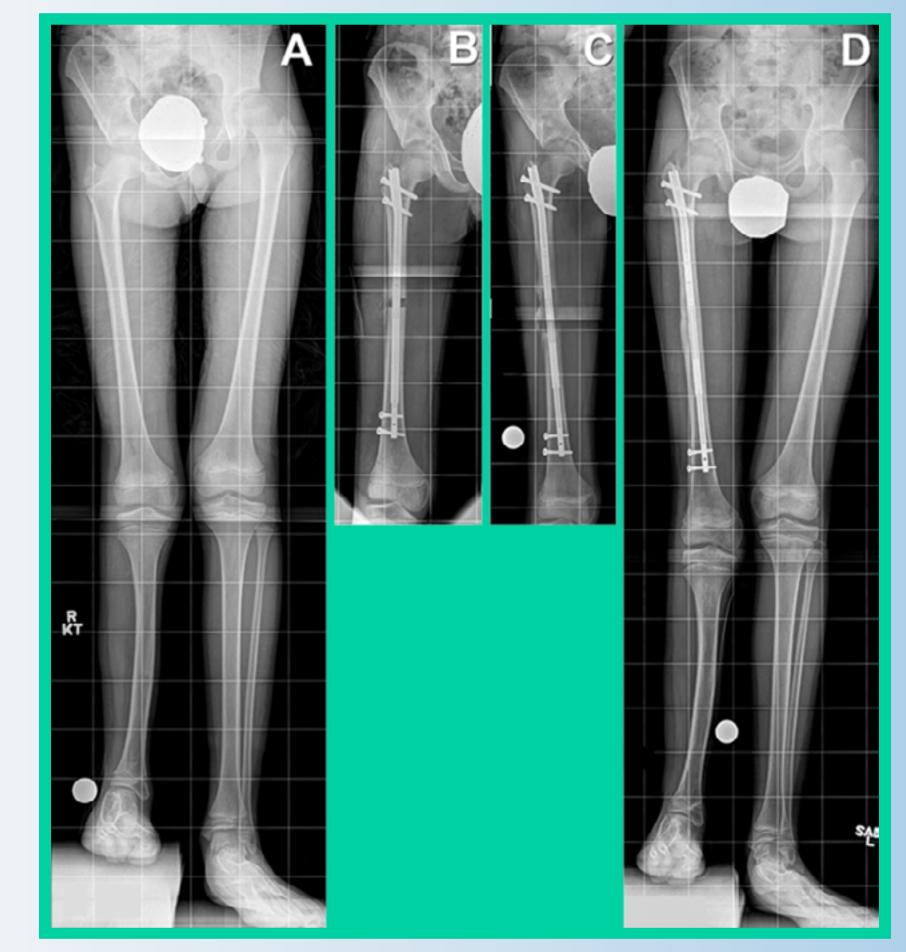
Eleven-year-old boy with congenital femoral deficiency and fibular hemimelia. Right limb is 5.5 cm shorter than the left limb. BMI percentile is within normal range. A, Preoperative AP view full length standing radiograph. B, Immediate postoperative AP view radiograph of the right femur. C, AP view radiograph shows distraction is completed. D, AP view full length standing radiograph shows the fully consolidated femur with the lengthening goal achieved. Tibia will be lengthened in subsequent treatment.
